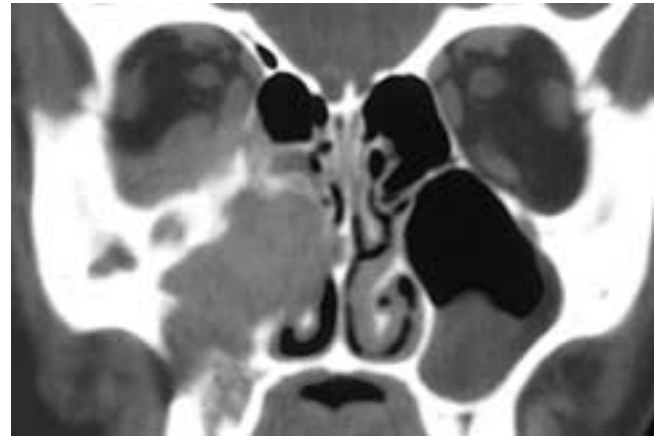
Coronal CT scan shows a soft-tissue mass in the right maxillary sinus. The medial sinus wall and portions of the antral roof are destroyed, and the tumor extends into the right orbit, ethmoid sinuses, and right nasal cavity. Despite these local areas of destruction, there are large areas where there is intact bone adjacent to the tumor. This patient had a rhabdomyosarcoma.
